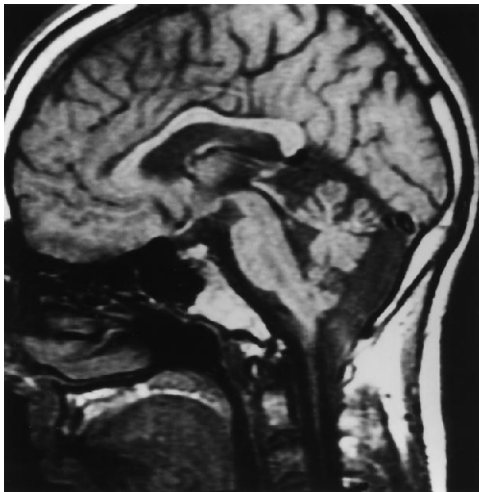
Sagittal T1-weighted baseline MR image shows cerebellar atrophy. There is no tonsillar ectopia. (The inferior aspect of the posterior fossa is seen in a slightly parasagittal projection; volume averaging causes the unusual appearance of the inferior medulla and the spinal cord.)
